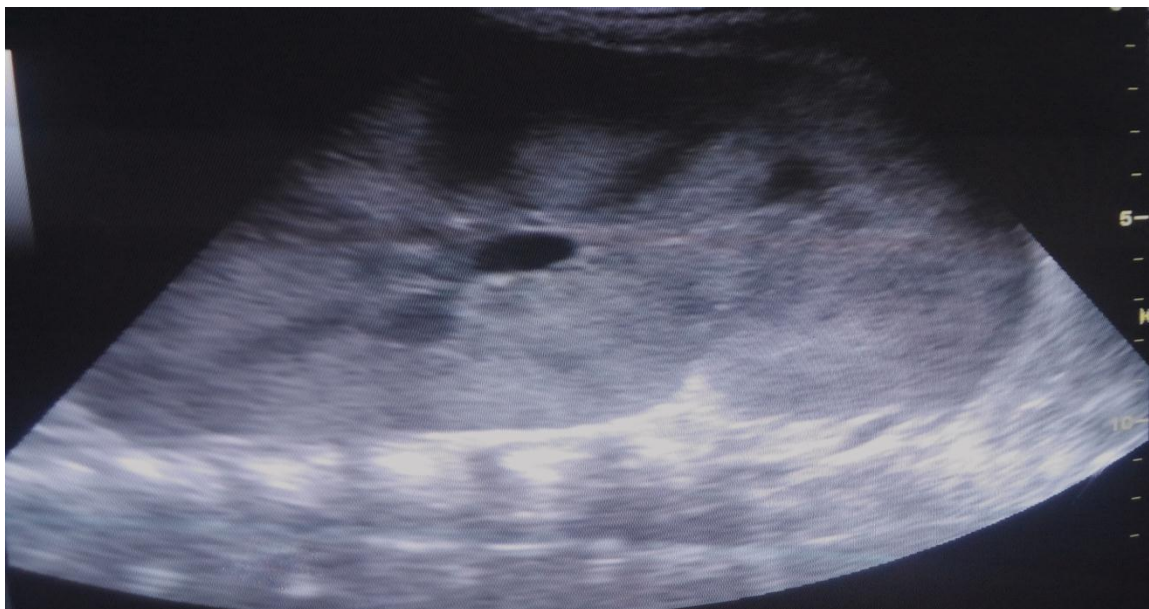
Longitudinal sonogram of a globular and echogenic left kidney in a 33-year-old female candidate with HIVAN.
